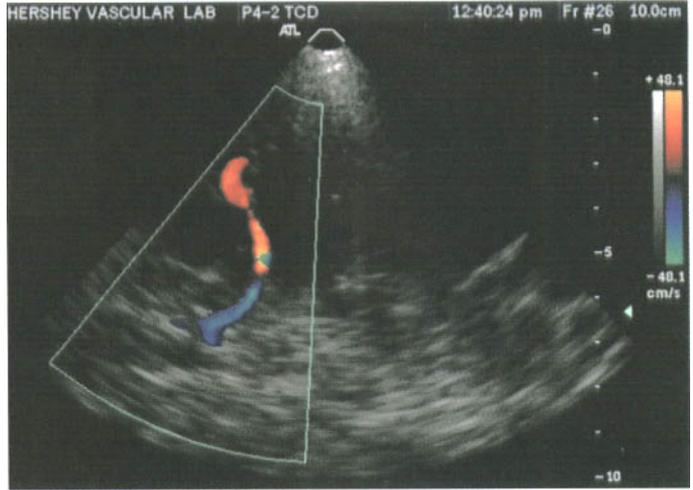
Color Doppler flow image of the anterior and middle cerebral arteries. Blue, anterior; red, middle cerebral artery.
